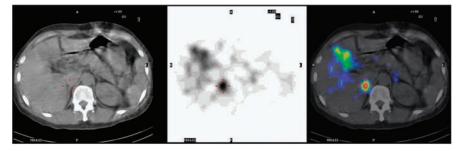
I-131 NP-59 SPECT/CT. Transaxial images of CT (left) and corresponding SPECT (middle) fused to the SPECT/CT (right) demonstrated intense radiotracer uptake within right adrenal gland (red-cross sign).
